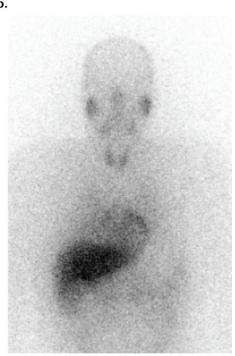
Findings in a 17-year-old boy with shortness of breath. (a) Axial contrast-enhanced CT image shows a middle mediastinal mass, which was subsequently sampled at biopsy; pheochromocytoma or paraganglioma was revealed. (b, c) The mass demonstrated <sup>68</sup>Ga-somatostatin analog uptake on the axial fused PET/CT scan (b) but lack of iodine 123 (123I)-metaiodobenzylguanidine uptake on the frontal anteroposterior static scintigram obtained 24 hours later (c).
